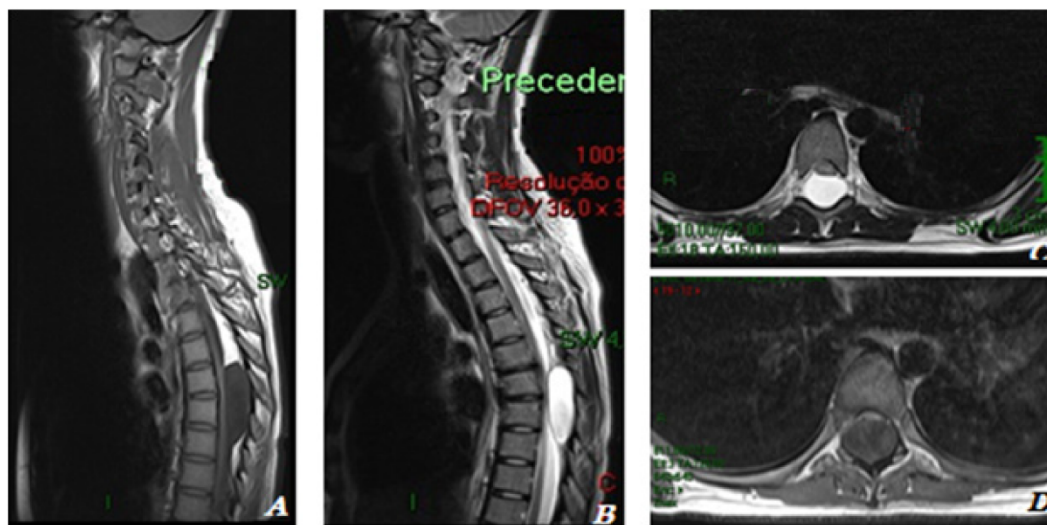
Pre operative T1-weighted sagittal MRI (A), T2-weighted sagittal MRI (B), T2-weighted axial MRI (C) and T1-weighted axial MRI (D). Observe how the lesion seems to be extradural on the posterior aspect of the dural sac and it has the same signal than the CSF.
